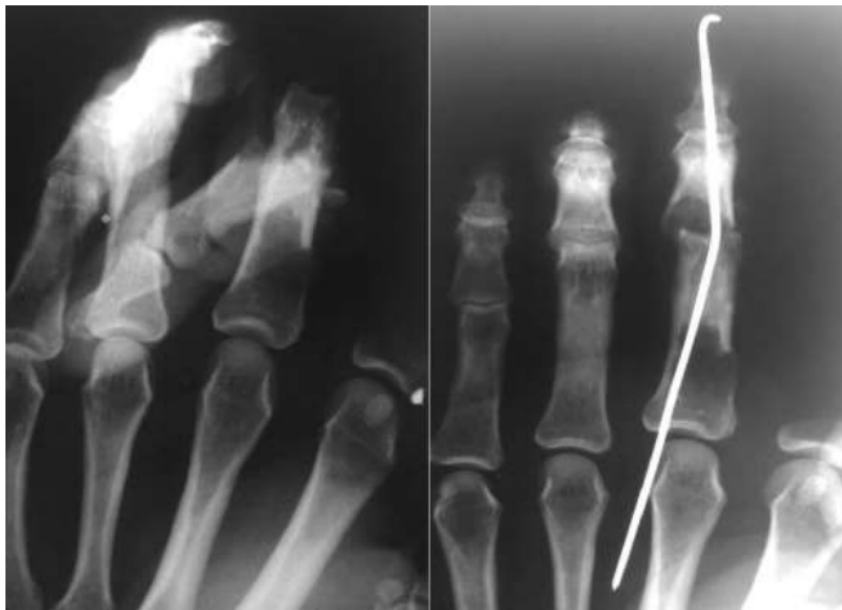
Radiograph of the left hand of patient D., 37 years old (after injury)
